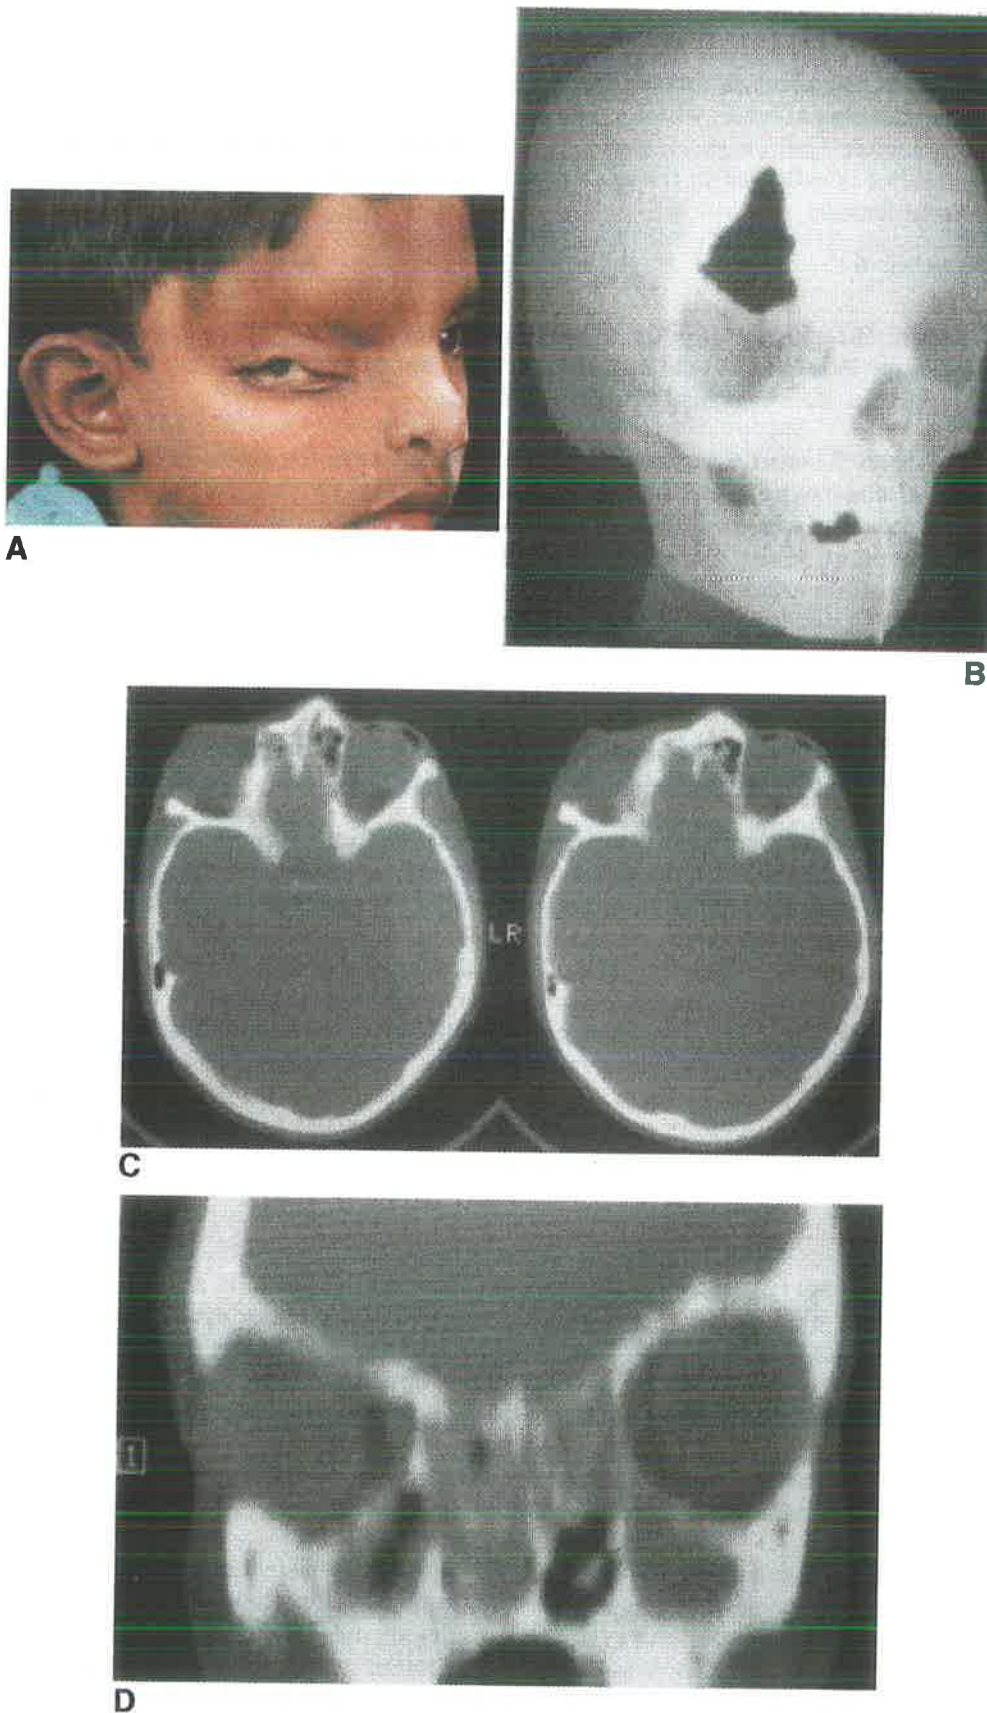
A. Eight-year-old Malaysian boy of Indian descent with multiple craniofacial clefts, including a Tessier Number 10 cleft on the right side. B. Frontal, supraorbital, and orbital roof bony cleft lateral to the supraorbital nerve. C. Axial two-dimensional CT scans through the orbits show the widening and lateral displacement of the cleft-side orbit. D. Asymmetry and inferior displacement of the cleft side orbit and anterior cranial fossa floor are evident on a coronal two-dimensional CT reformat.*
